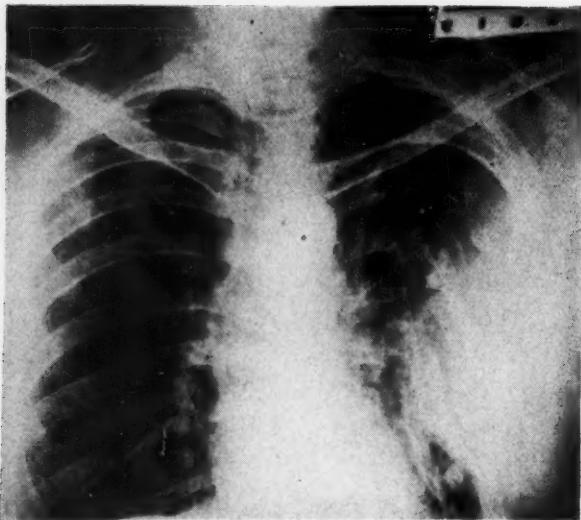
Case 2. September 19, 1945: Roentgenogram showing amount of collapse, and regeneration of ribs, which add support to the chest wall. No evidence of abscess cavity.
